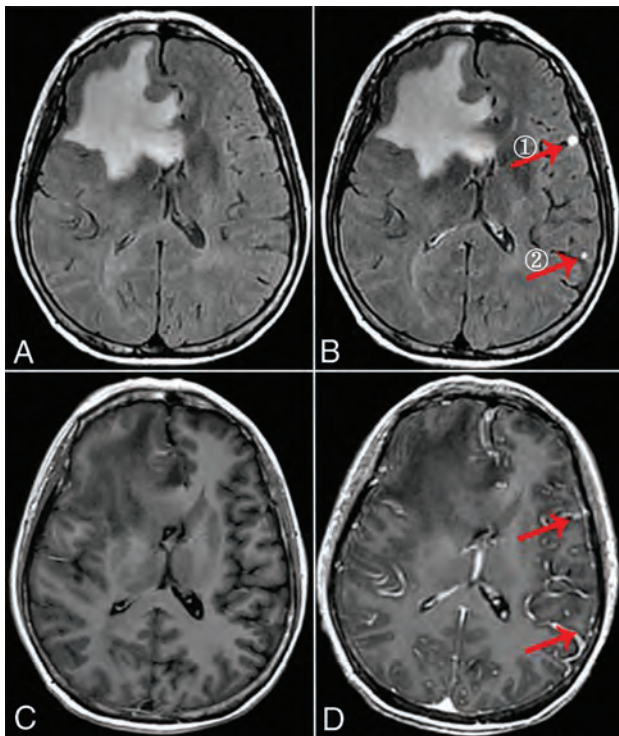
A 56-year-old woman with small brain metastases (① and ②, <5 mm, arrow). A, Nonenhanced T2 FLAIR. B, Phase 3 half-dose CE-T2 FLAIR (①, 3 points; ②, 3 points). C, Half-dose CE-T1WI completely missed the lesions. D, Routine-dose CE-BRAVO (①, 1 point; ②, missed diagnosis).
